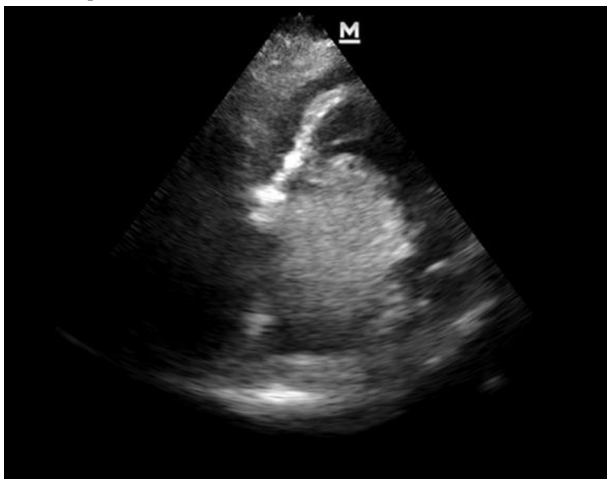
Transthoracic echocardiography in modified four – chamber view shows a large mass in right atrium with functional tricuspid stenosis and mild pericardial effusion
